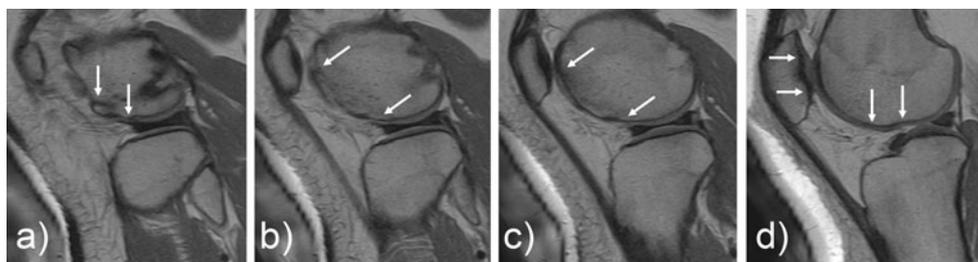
Sagittal PDW-TSE (a–d) MRI of a morbidly obese young male patient, 15 years of age, with a height of 168 cm, a weight of 170 kg, exceeding a BMI of 60.2 kg/m^2 . The patient complained of severe knee pain for 2 years; it was observed that the intensity of the pain was directly correlated with the young patient gaining weight. The mean VAS score was 5, and the motion of the knee was slightly
